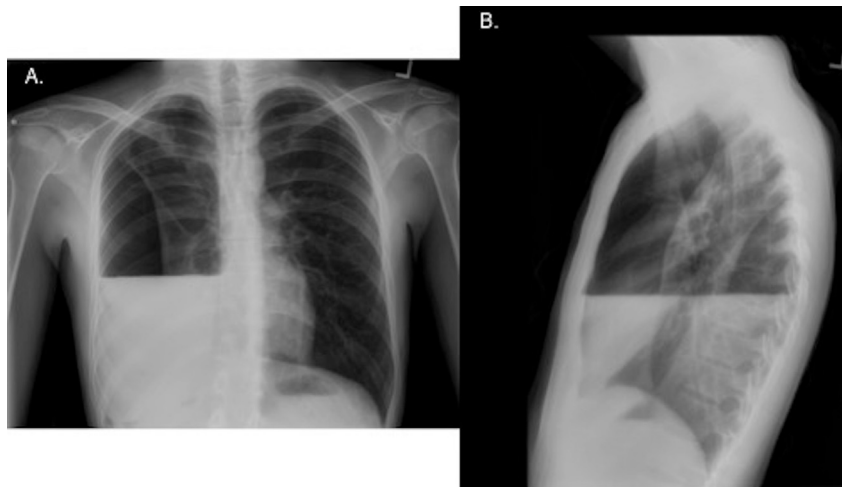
Initial chest radiographs of patient upon presentation. A, Posteroanterior view showing large right hydropneumothorax. B, Lateral view showing hydropneumothorax.
